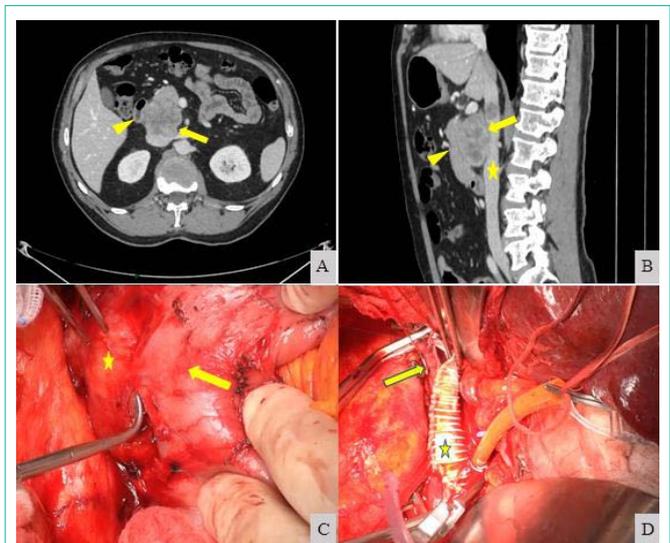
Clinical case #2: A) CT scan of soft tissue mass (arrow) near duodenal right wall (arrow head); B) CT scan of soft tissue mass (arrow) in contact with duodenum (arrow head) and inferior vena cava (star); C) Intraoperative view of leiomyosarcoma (arrow) adhering duodenal right wall (arrow head); D) Intraoperative view of inferior vena cava (arrow) reconstruction with a PTFE vascular prosthetic patch (star).
